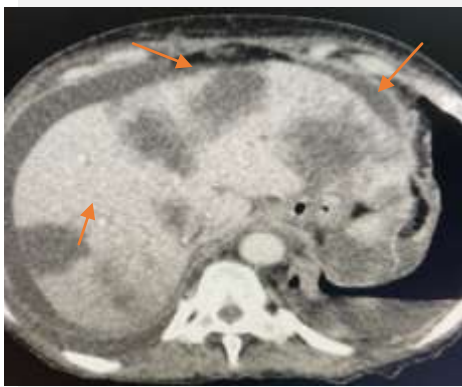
Abdominal CT in axial section parenchymal window in the portal phase highlighting multiple diffuse hypodense hepatic nodules with irregular contours of secondary appearance.
